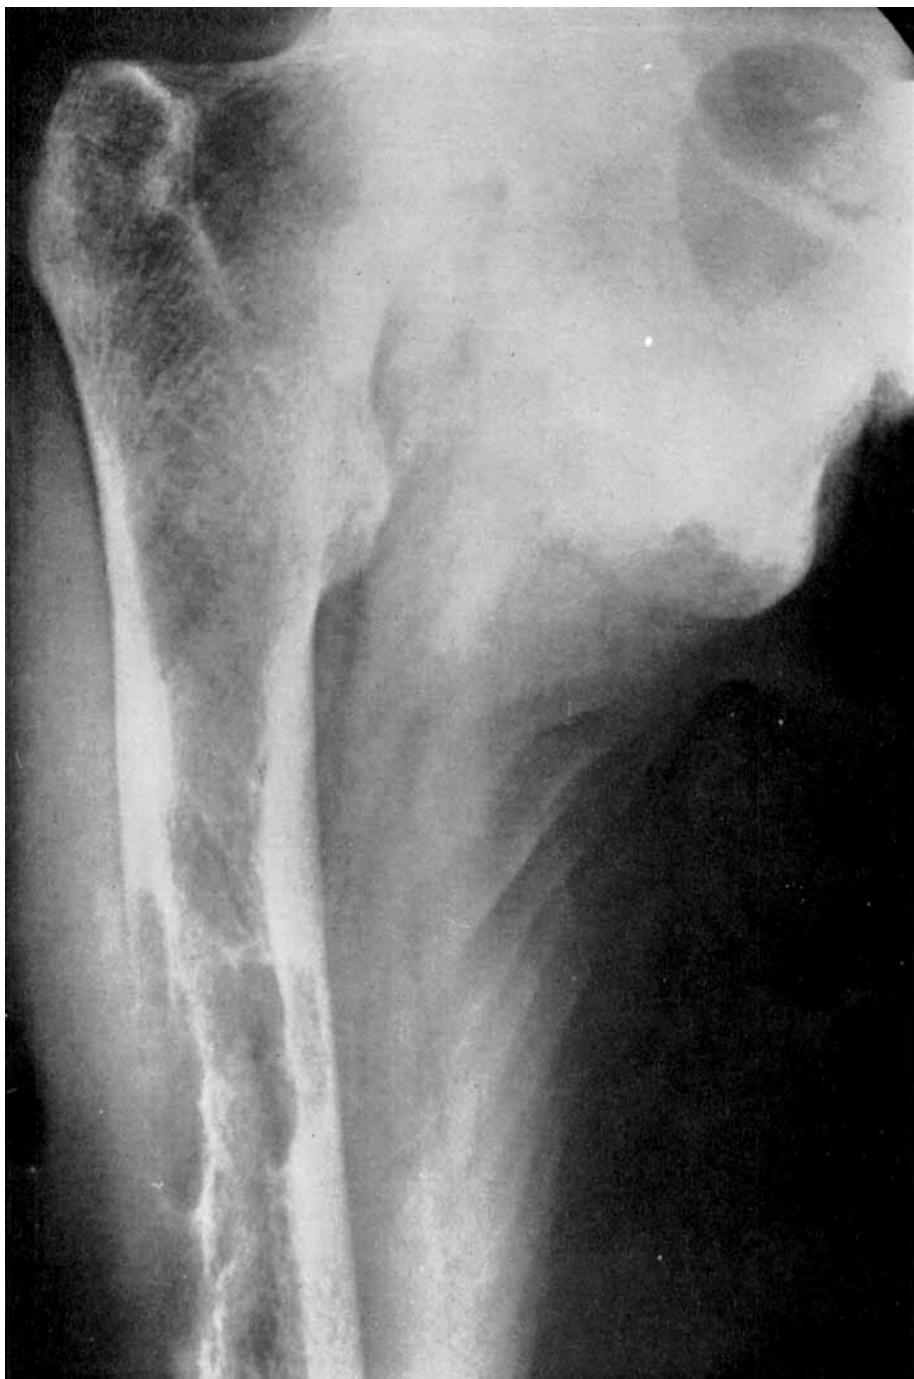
X-ray photograph of right femur in March 1944, showing the rarefaction and localised “fibrocystic” changes which led to further investigation and treatment. After a period of improvement similar changes reappeared. The degree of rarefaction can be gauged by comparing the density of the bone cortex with that of the muscle shadows.
